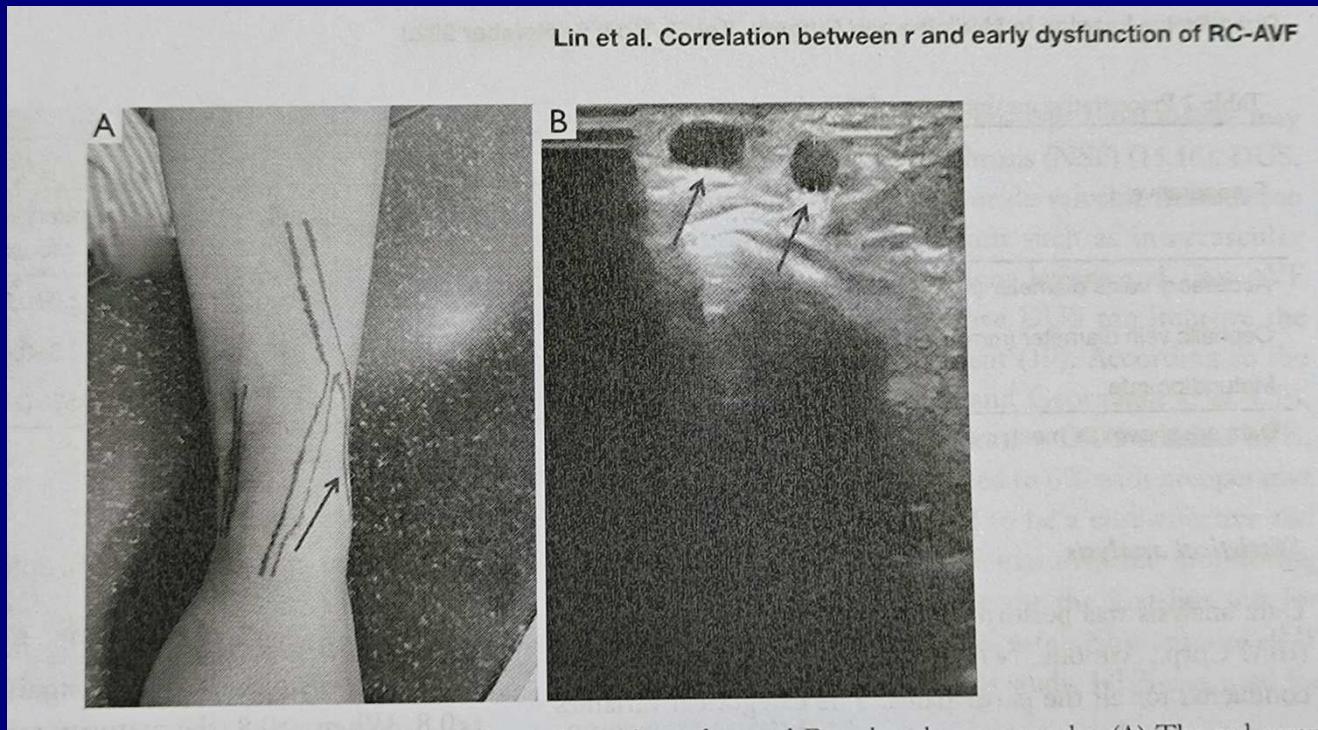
The relative position of the ACV and the cephalic vein on the body surface and Doppler ultrasonography. (A) The red arrow indicates the body surface where the ACV drains into the cephalic vein; (B) the red arrows indicate the position of the cephalic vein (left) and the ACV (right) on the Doppler ultrasonography. ACV, accessory cephalic vein.
